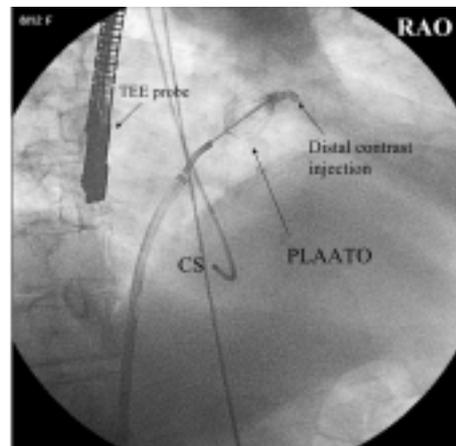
Fluoroscopic right anterior oblique (RAO) image of dye distal injection after PLAATO implantation. It is clearly visible the absence of leak as the dye is confined beyond the device. This is an objective sign of PLAATO well left atrial appendage sealing. CS = coronary sinus; TEE = transesophageal echocardiography.
